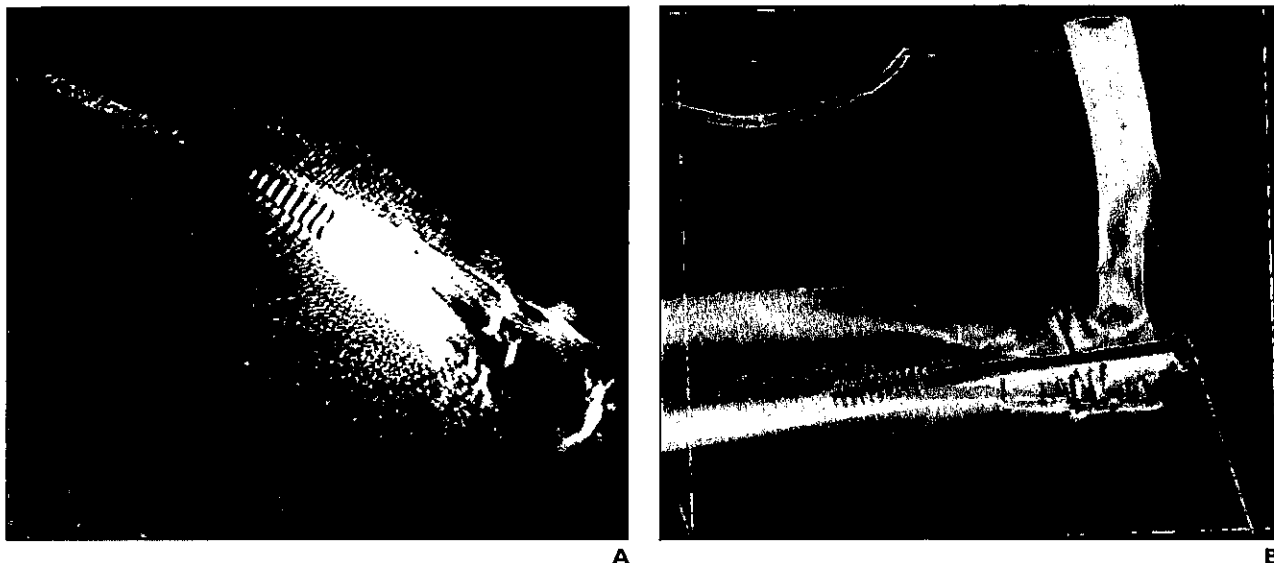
41-year-old woman with transolecranon fracture—dislocation of left elbow after motor vehicle collision requiring open reduction and internal fixation. A, Coronal multiplanar reformatted image provides limited evaluation because of streak artifact. B, Sagittal 3D CT image shows satisfactory alignment of fracture fragments and hardware.
